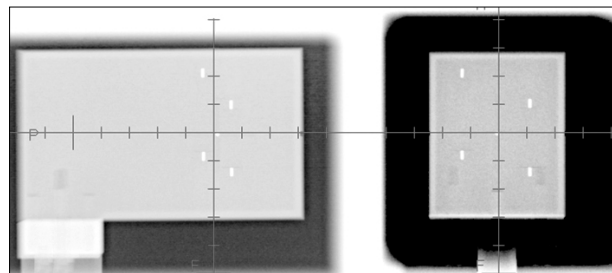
Lateral (left) and anterior (right) views of a 2D radiograph of the marker block; five radiopaque markers are shown on both radiographs.
